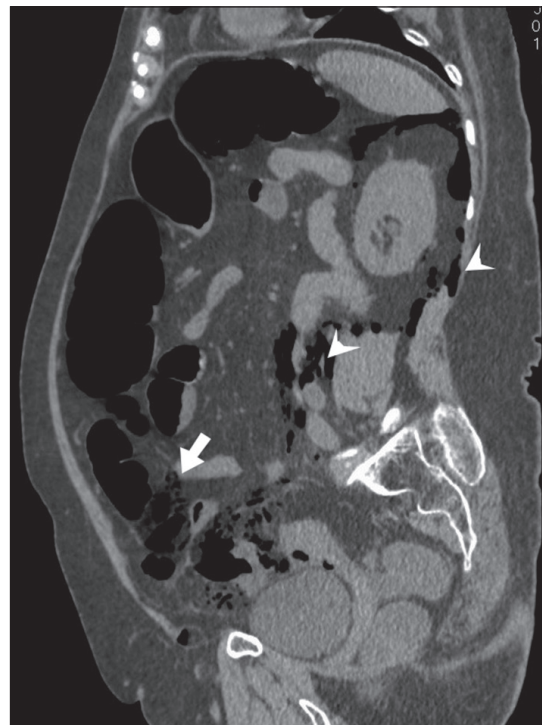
In this sagittal section of the CT scan the diverticular perforation is marked with an arrow and the free air in the retroperitoneum is marked with the arrowheads.
